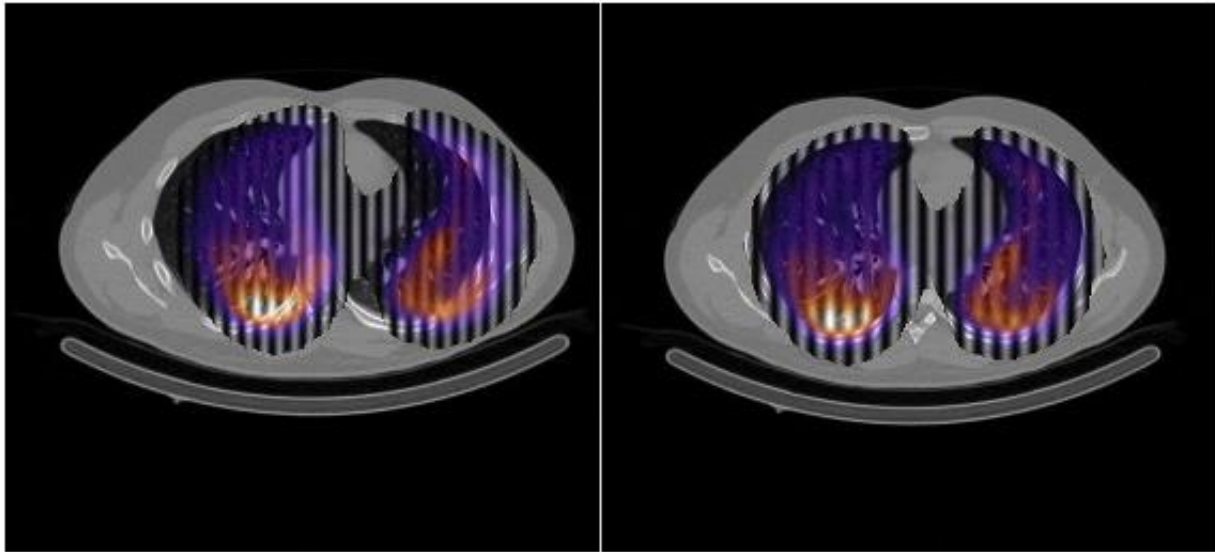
VSPECT and CT images taken from the dataset for an asthmatic subject to show the process of registration. Image registration is performed to ensure that VSPECT and CT images were well-aligned. Left image shows CT and VSPECT before registration. Right image shows CT, and VSPECT after registration.
